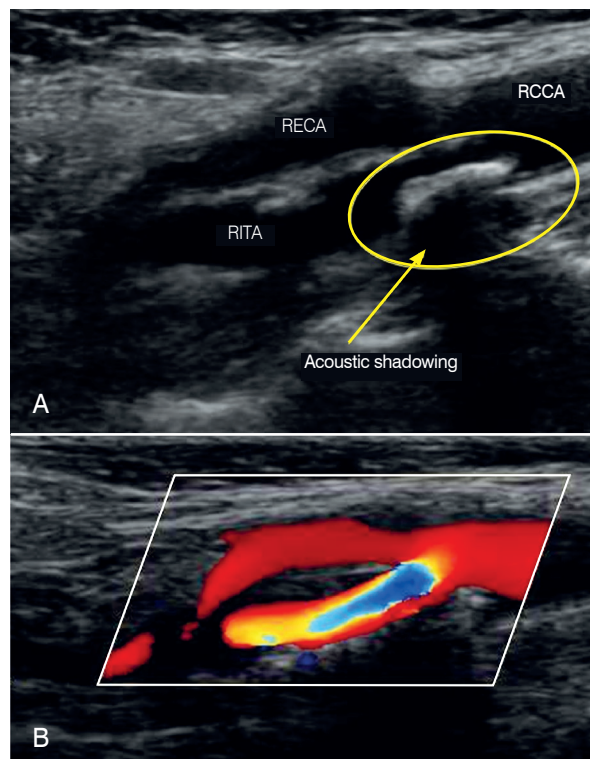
A) Ultrasound allows the diagnosis of atheroma plaques in the carotid arteries, which indicate the presence of systemic atherosclerosis and a higher risk of the occurrence of adverse cardiovascular events. In this example, a calcified plaque defined by the existence of acoustic shadowing (arrow) in the distal portion of the right common carotid artery (RCCA) is present, which also compromises the origin of the right internal carotid artery (RITA) but does not affect the right external carotid artery (RECA). B) In addition to revealing atheroma plaques, ultrasound enables other measurements, such as the impact of stenosis on arterial flow. In this example, color Doppler reveals a significant change in flow due to the presence of stenosis.
